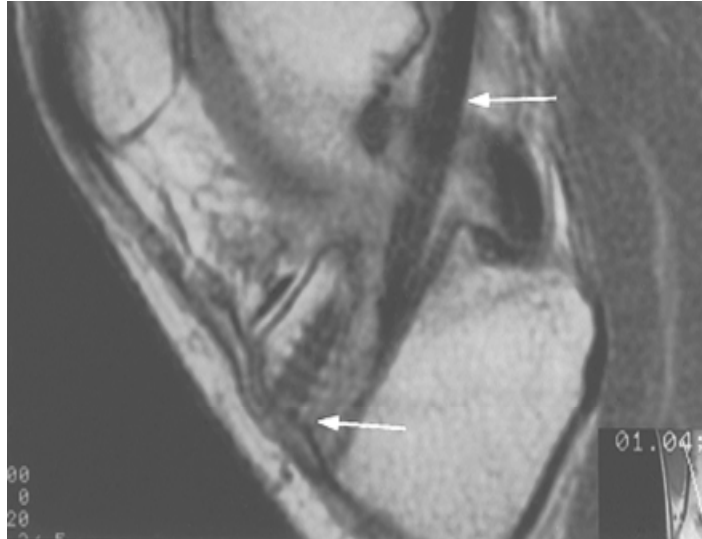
This MR image shows the interference screw (bottom arrow) has not degraded at 6 months following implantation (top arrow indicates the graft tissue) (Bach, et al.).
